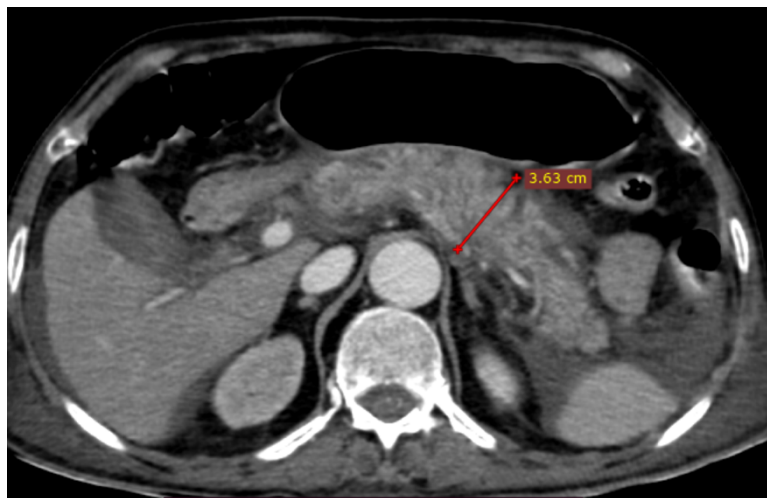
(B): CT: Swollen pancreas with peripancreatic fat stranding and fluid collection.
